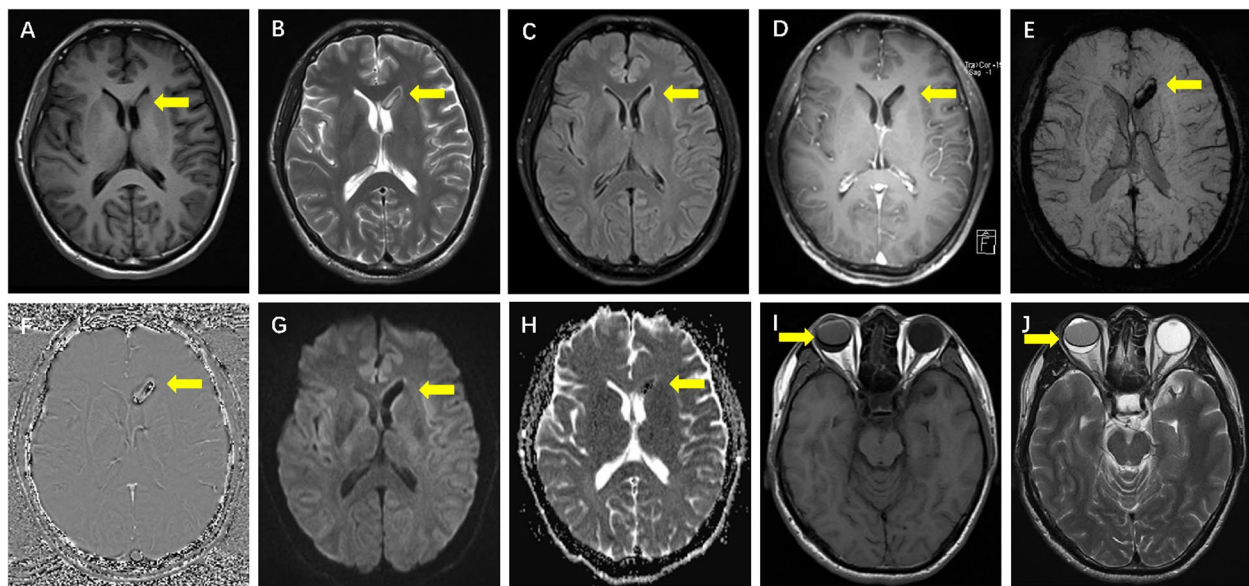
The abnormal signals in the anterior horn of the left lateral ventricle on MRI (A–H, yellow arrow). Brain MRI revealed abnormal signals in the left lateral ventricle anterior horns, showing hyperintensity (similar to the cerebrospinal fluid), surrounded by low-signal chemical shift artifacts, on T2WI (B); inconspicuous on T1WI (A), on FLAIR (C) and enhanced T1WI (D); hypointensity on SWI (E) and on DWI (G). Hybridintensity on SWI phase-image (F) and on ADC (H). The signal of the right eyeball filled with silicone particles was consistent with brain parenchyma on T1 and T2 respectively, however, inconsistent with the contralateral eyeball (I, J)
